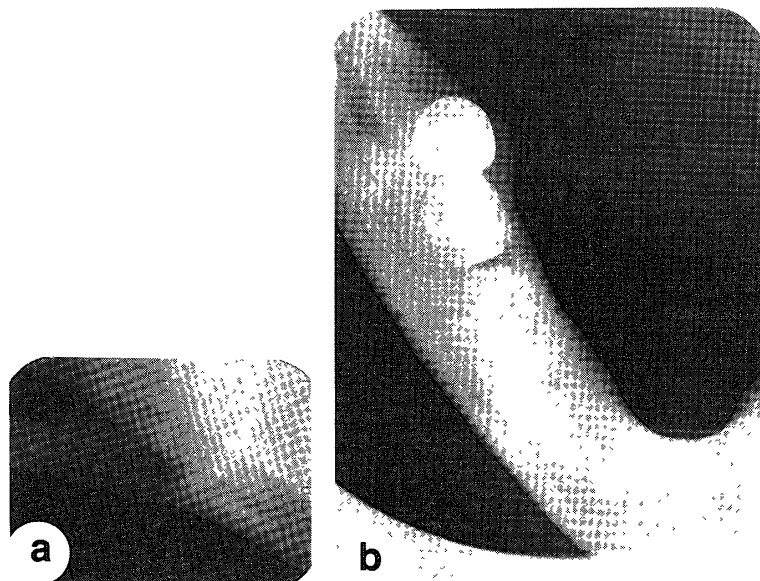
Periapical (a) and axial (b) radiographs obtained at the first admission.
